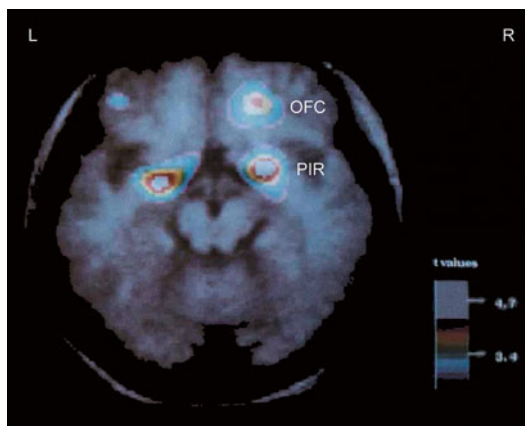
The first functional imaging study of human olfaction. In this PET study by Zatorre et al. in 1992, odor stimulation was associated with significant neural activation in piriform cortex (PIR) bilaterally and in orbitofrontal cortex (OFC) on the right side. Responses are overlaid on an axial section of the subject-averaged anatomical MRI scan. (Reprinted and modified from Zatorre et al. (1992) by permission from Macmillan Publishers Ltd.)
